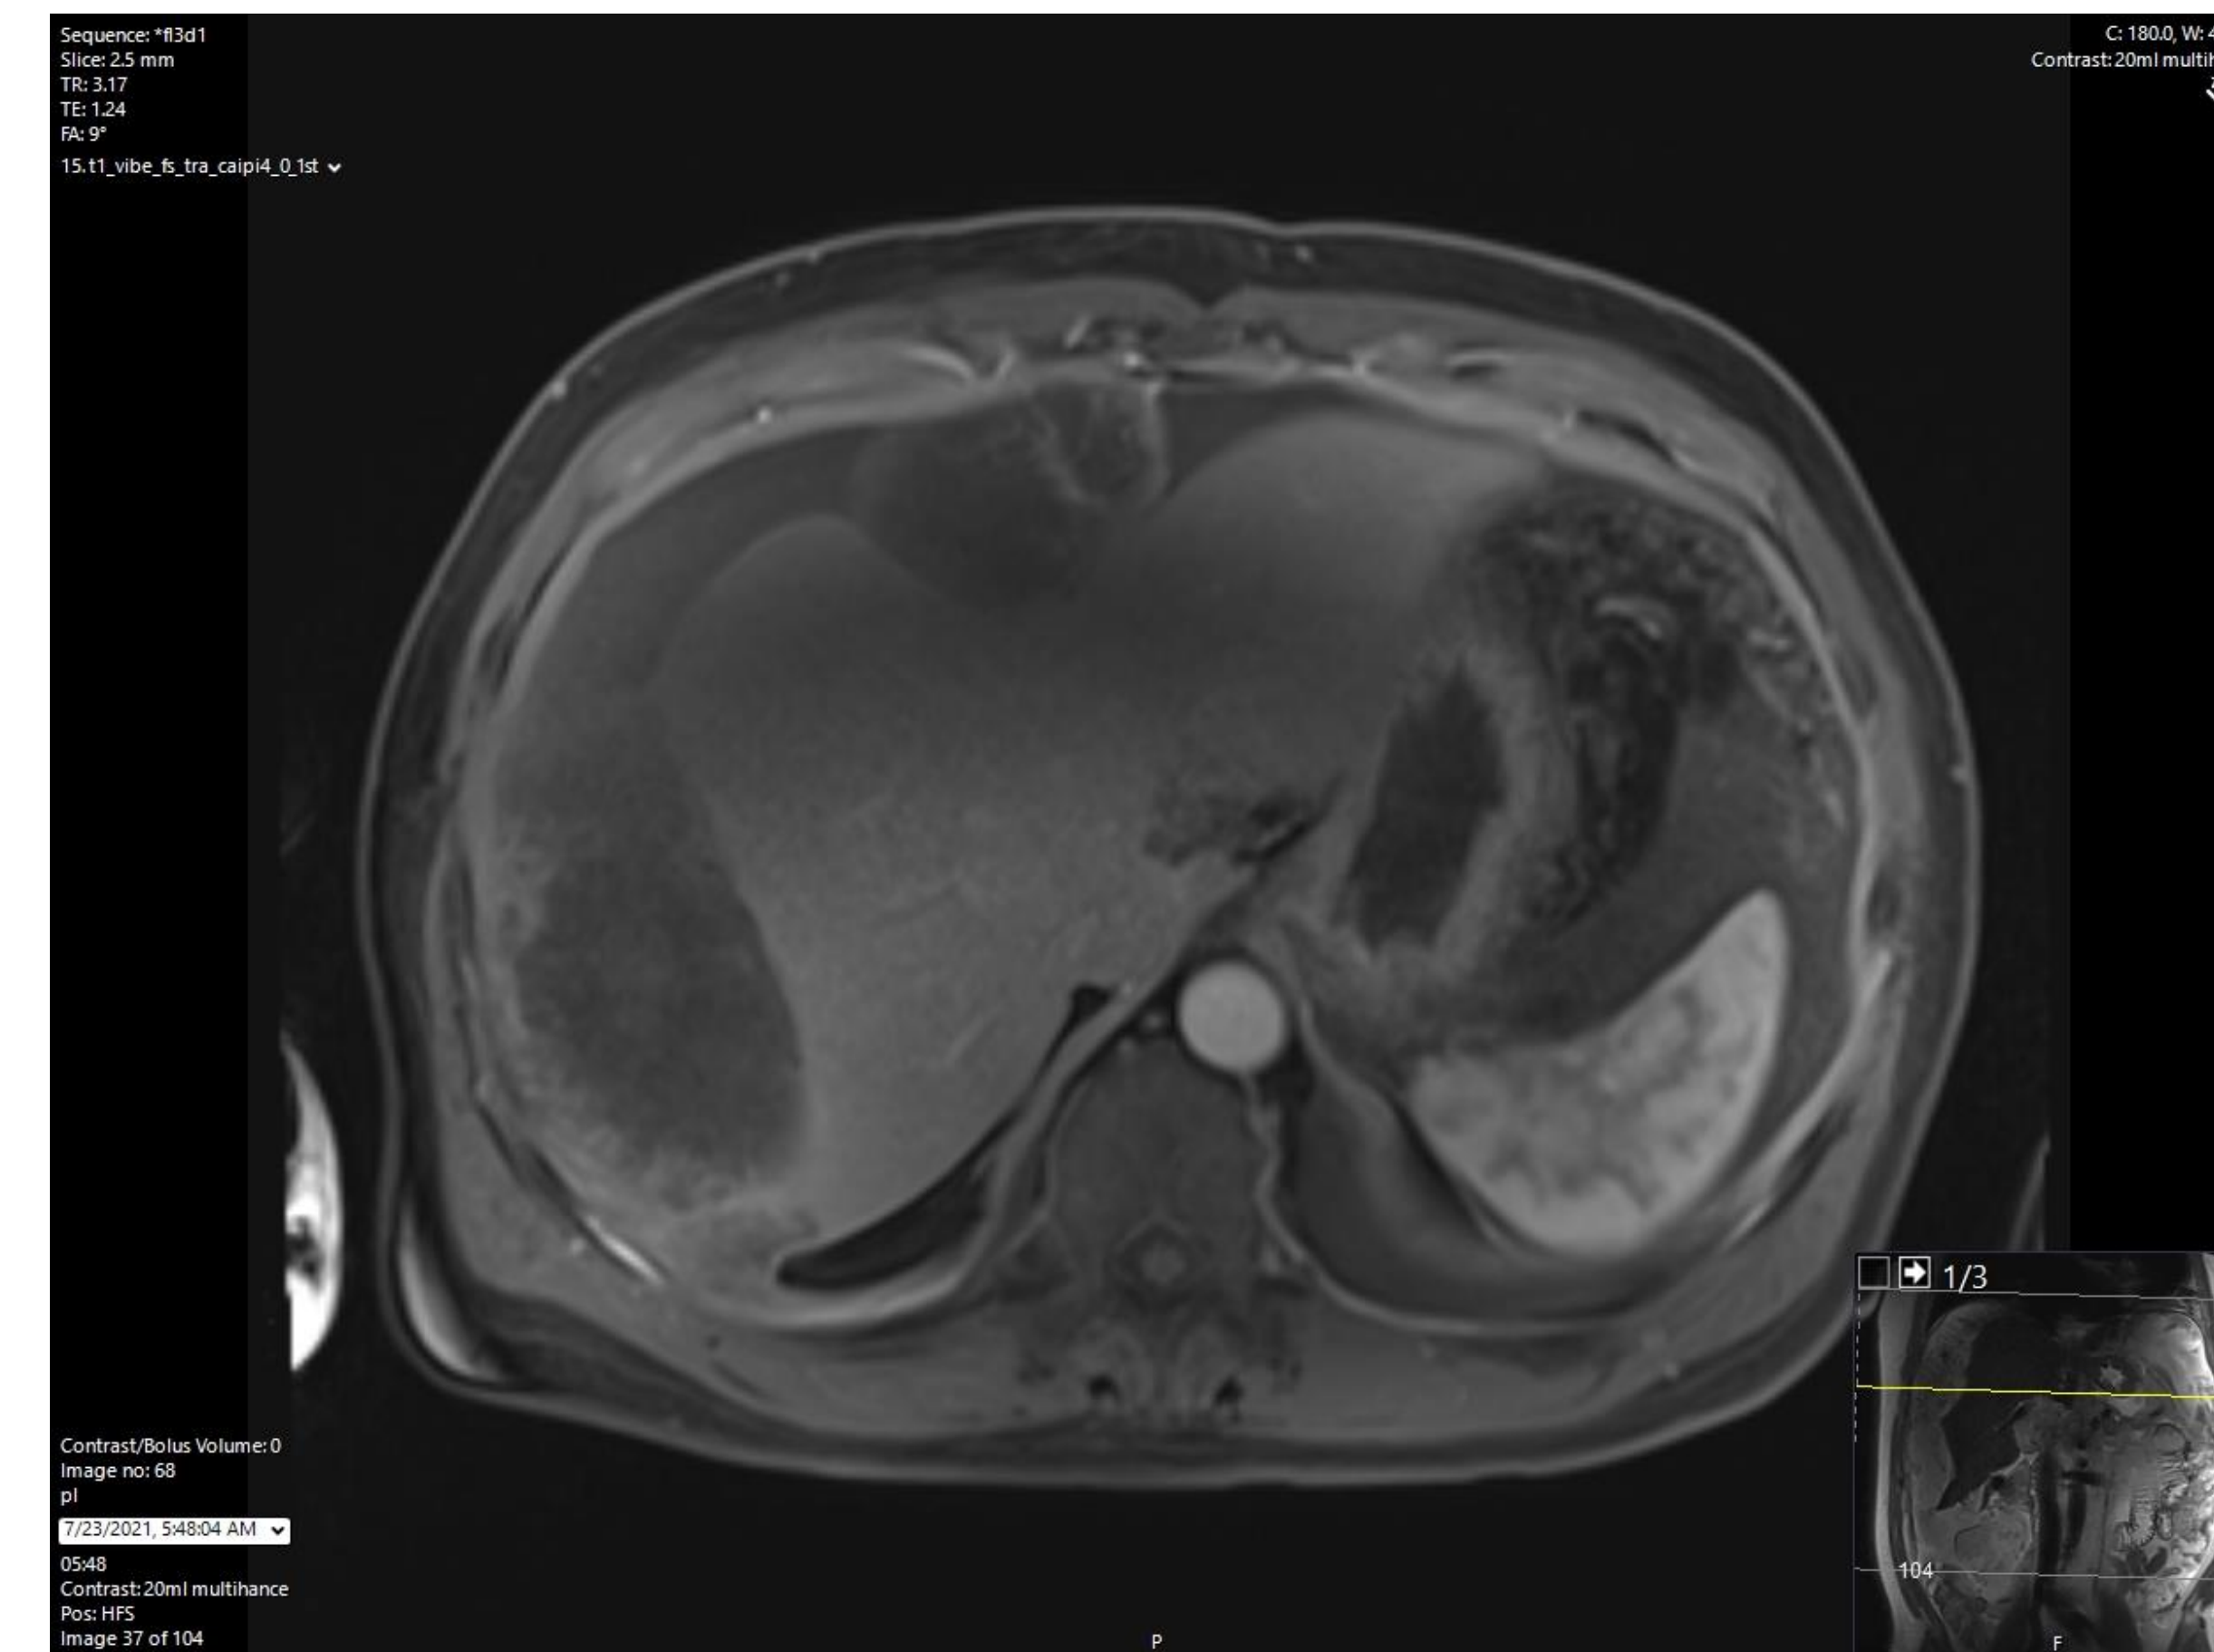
MRI showing scalloping of the liver due to pseudomyxoma peritonei
